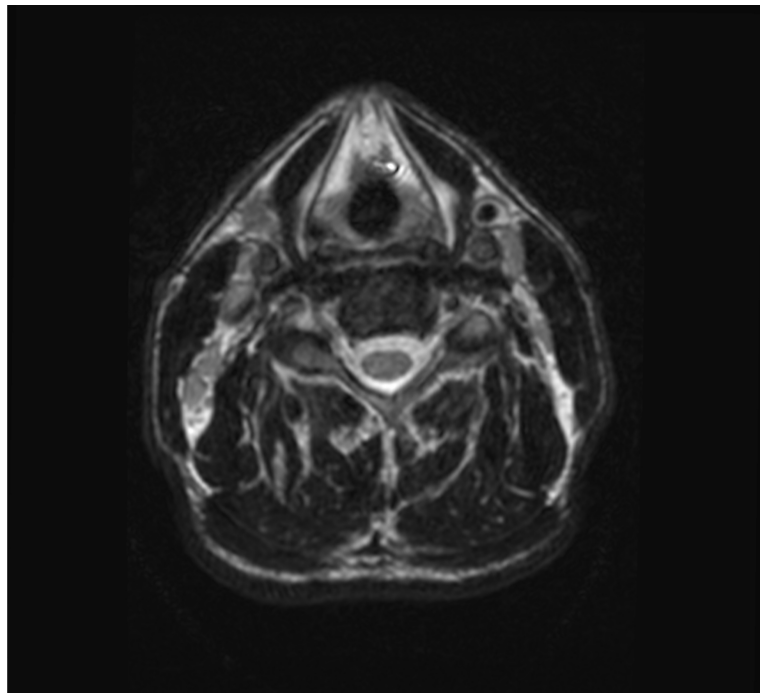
Axial image from MRI in 3D Cube Nerves, to start the quantitative measurements of the nerve roots to analyze.
